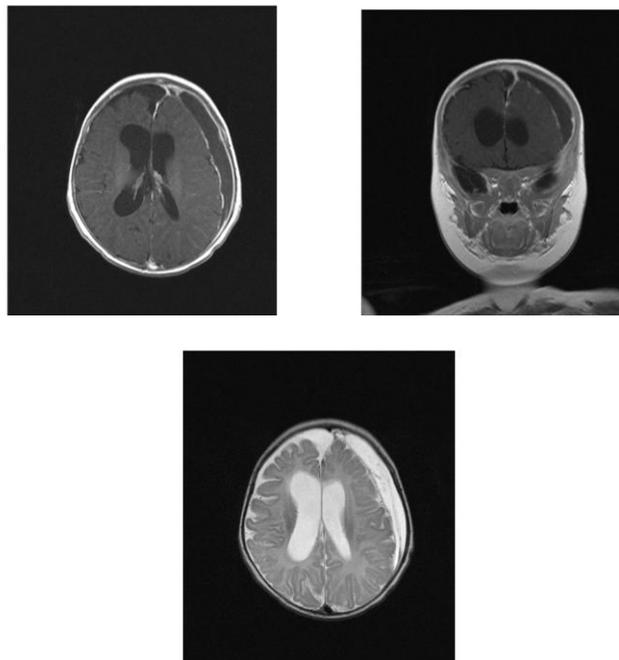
MRI images of subdural hematoma.
